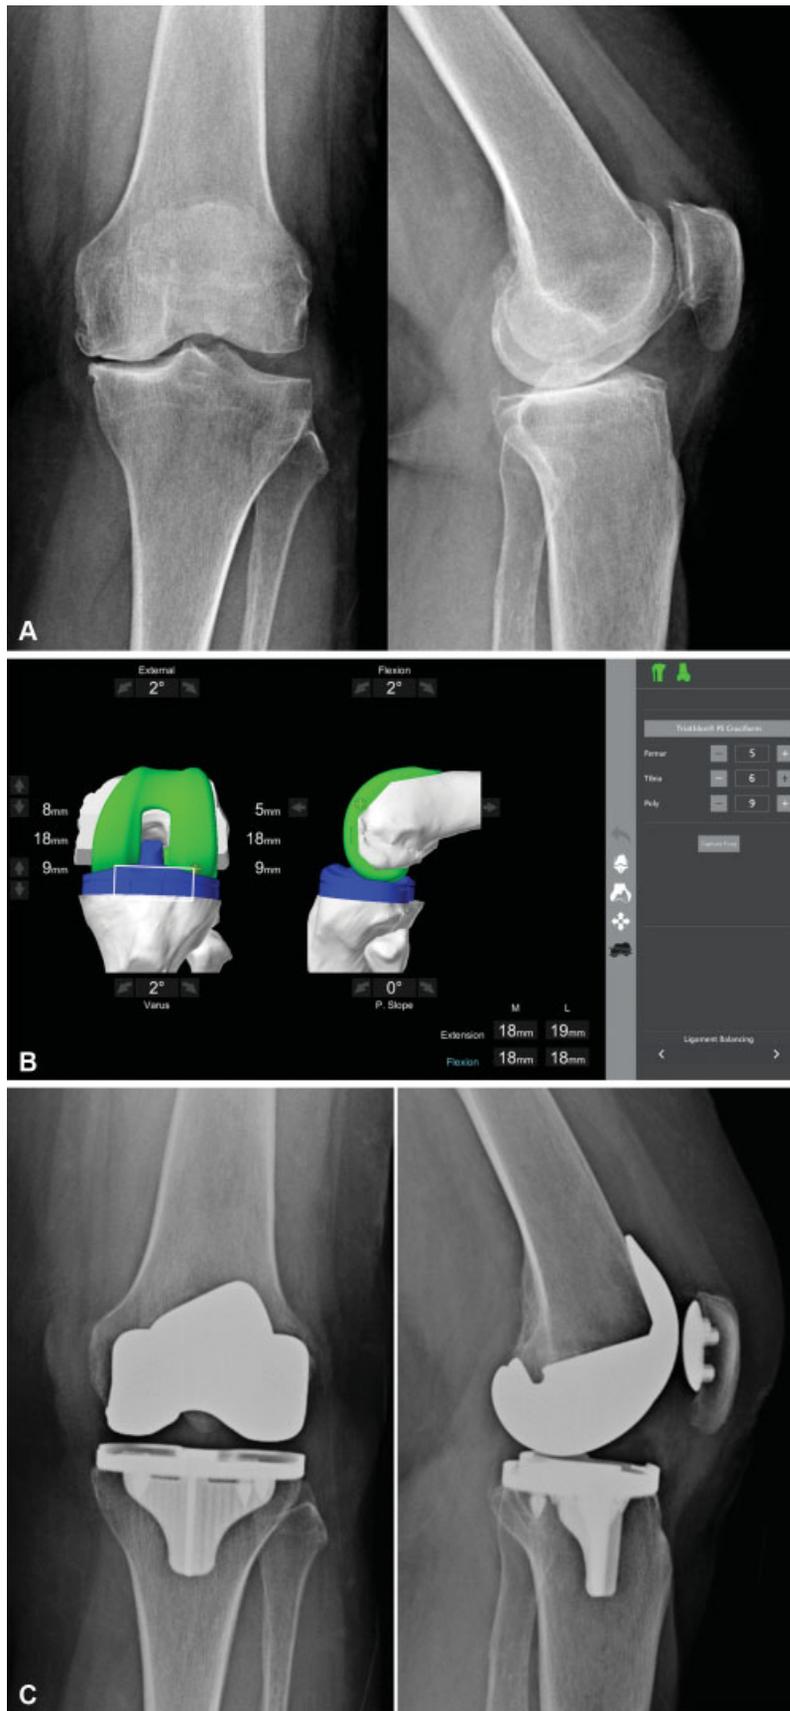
(A) Preoperative AP and lateral radiographs of a 73-year-old female with left knee OA undergoing robotic assisted with intraoperative computer technology total knee arthroplasty (TKA). (B) Final intraoperative medial and lateral flexion and extension gap measurements within 1 mm with components in place. (C) Postoperative AP and lateral radiographs following robotic assisted with intraoperative computer technology TKA. AP, anteroposterior; OA, osteoarthritis.
